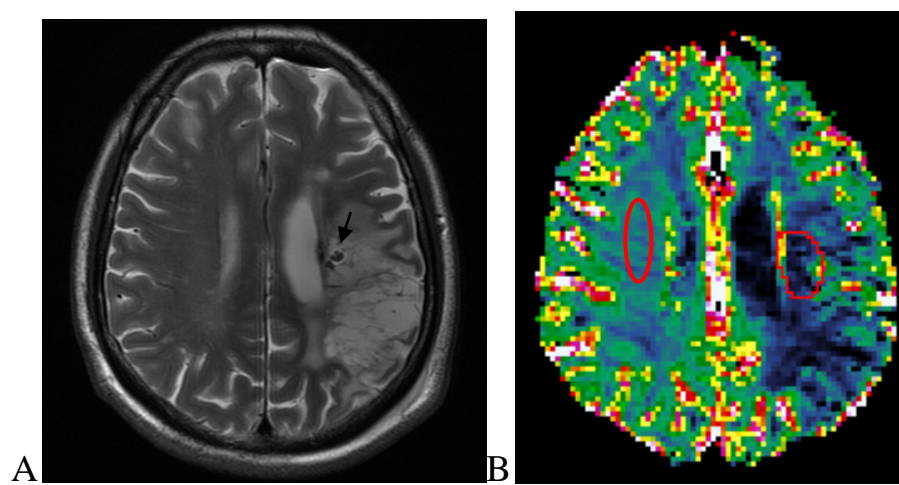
Draw the regions of interest on MR perfusion image. A) T2-weighted FSE axial image showed focal hypointensity (arrow) resulted from the SPIO labeled on the stem cells in the peri-infarct area 1-day after implantation. B) The measured ROIs (red circles) showed on the relative blood volume map of MR perfusion study.
